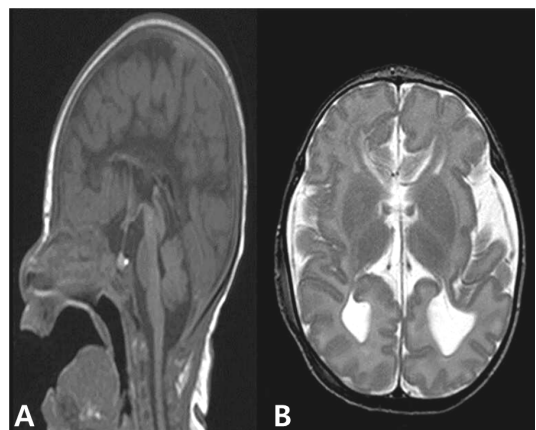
Brain magnetic resonance imaging (MRI) of the patient with Vici syndrome at the age of 2 months. Sagittal T1 MRI showing agenesis of the corpus callosum (A). Axial T2 MRI showing ventriculomegaly and cerebral atrophy (B).
